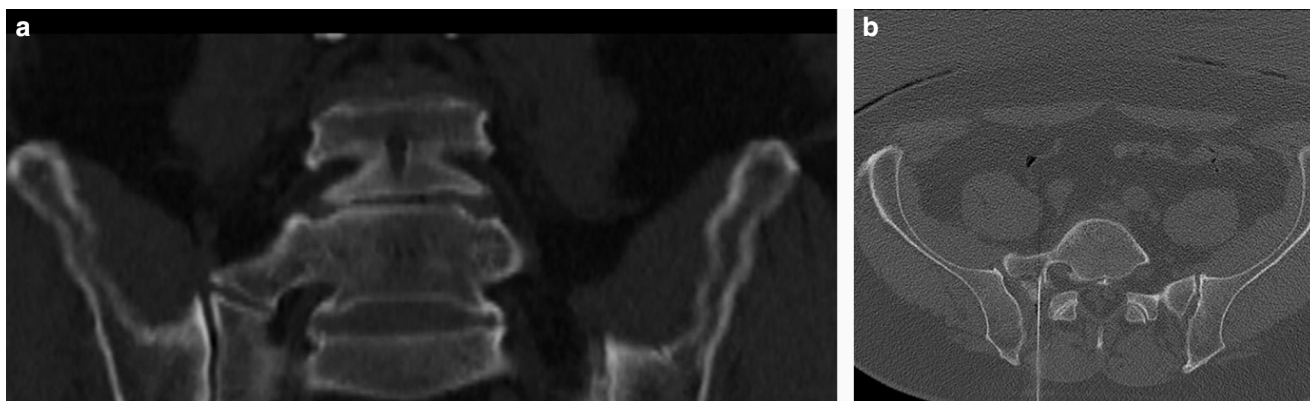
a: identification of landmarks by computed tomography; b: injection under computed tomography guidance.
